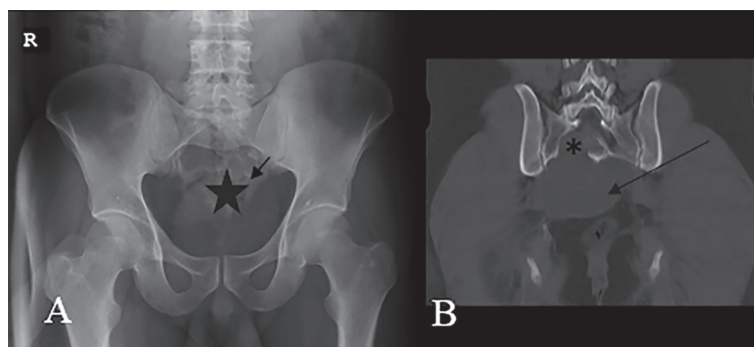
This figure shows sacral hydatid disease in a middle-aged man with chronic vague pelvic pain. A. Anteroposterior (AP) pelvic radiograph shows a massive destructive bone lesion in the lower segments of the sacrum without dystrophic calcification (asterisk) with faintly visible adjacent soft tissue mass (arrow). B. Coronal non-contrast enhanced pelvic CT shows a soft tissue mass with adjacent bone destruction which extends through the right sacral foramen into the spinal canal (asterisk). This figure was obtained from a patient who was admitted to the authors' institution and was not previously published.
